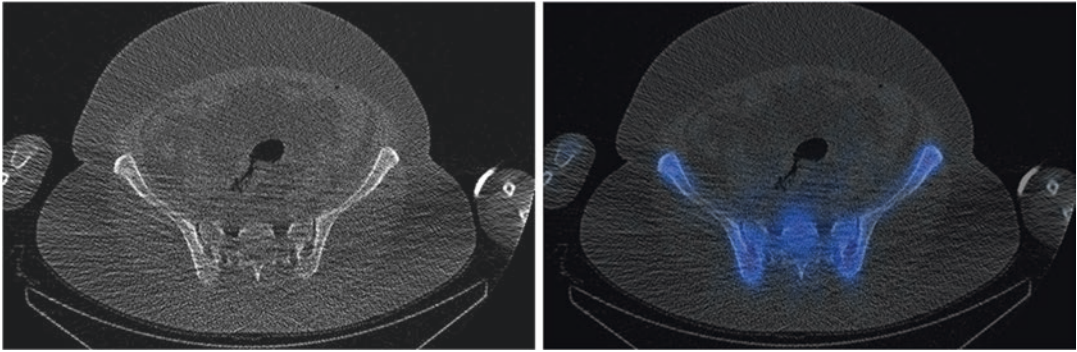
(a–c) Misregistration: Known carcinoma prostate, whole-body bone scan (a) shows multifocal uptake in the left rib, lower lumbar spine and pelvic bones. SPECT/CT of the lumbar spine and pelvis (b) localizes the uptake in the lumbar region to the left L3–L4 facet joint (arrow); however, fused coronal image shows gross misregistration
